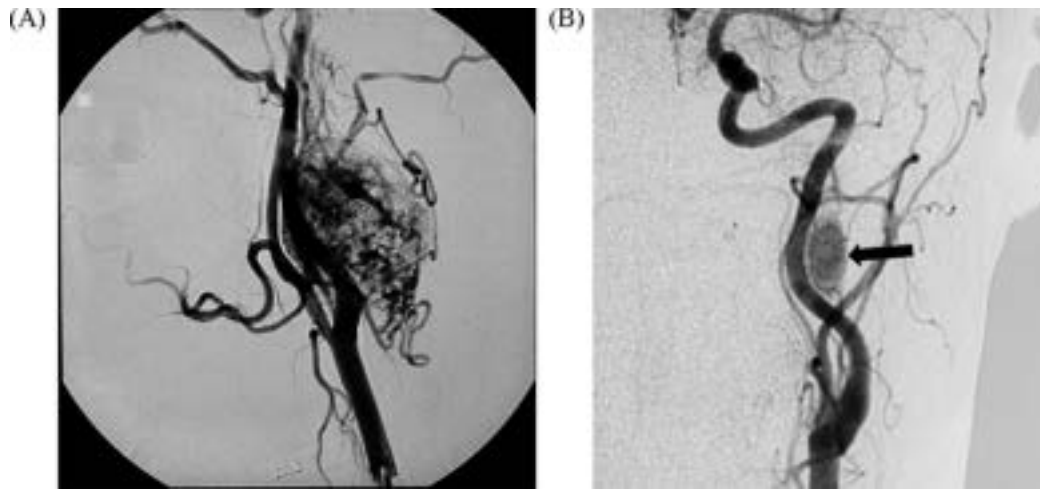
Angio-MRI of the lesions: (A) A hypervascular lesion in the right parapharyngeal space, which has displaced the internal carotid artery anteromedially without angiographic sign of adventitial infiltration. The lesion is supplied by the occipital and ascending pharyngeal artery. (B) The tumor on the left (arrow) in the contralateral parapharyngeal space is supplied by the external carotid artery.
